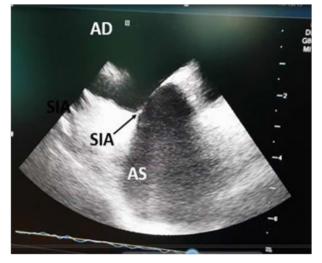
Intracardiac echocardiography during pulmonary vein isolation. The interatrial septum lies between the left atrium and the right atrium. Fossa ovalis is the thinnest part of the septum. Transseptal puncture should be performed at the level of fossa ovalis.
